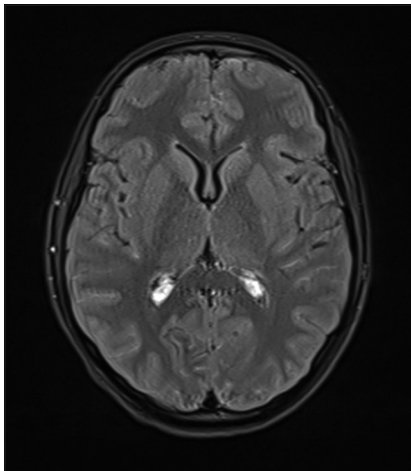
Contrast-enhanced magnetic resonance imaging brain showing leptomenigeal enhancement in bilateral cerebral hemispheres
